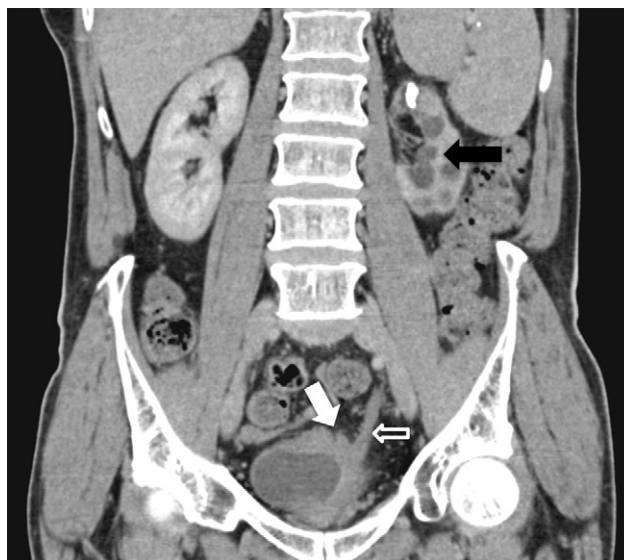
Urinary tuberculosis. Oblique coronal view contrast-enhanced CT scan: the bladder wall is thickened, calcified and retracted (white arrow), there is dilation of the ureter (arrow outline) and sequellar changes to the renal parenchyma, with calyx stenosis and calcification of the parenchyma (black arrow).
